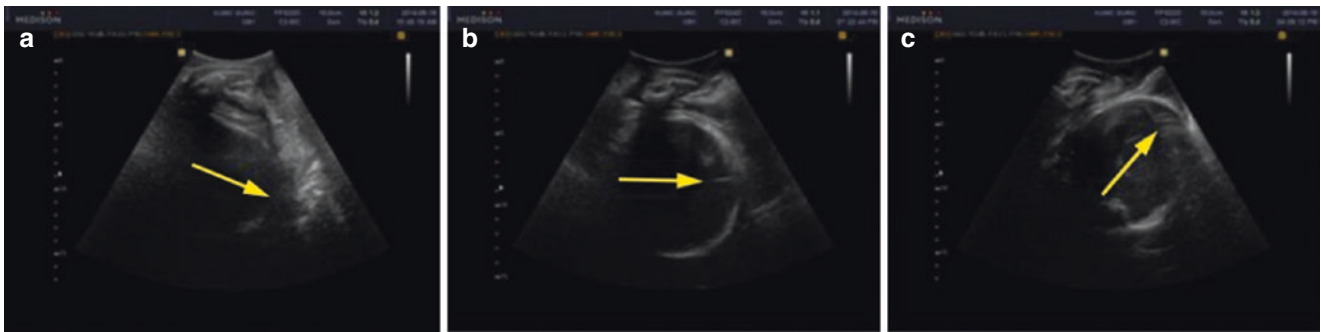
Head direction on intrapartum translabial ultrasound. Categorization of fetal head direction (indicated by arrows) in longitudinal translabial sonograms: (a) downward, (b) horizontal, and (c) upward direction (By Ahn and Oh [78])
